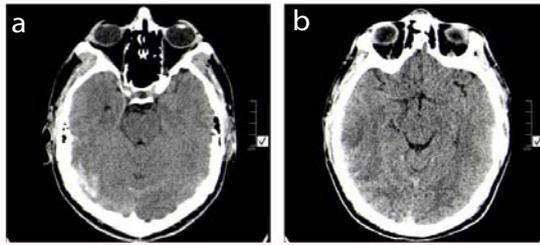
(a) Unenhanced CT demonstrates a right subdural hemorrhage along the tentorium. (b) More cephalad image demonstrates right temporal lobe edema, likely cytotoxic.
